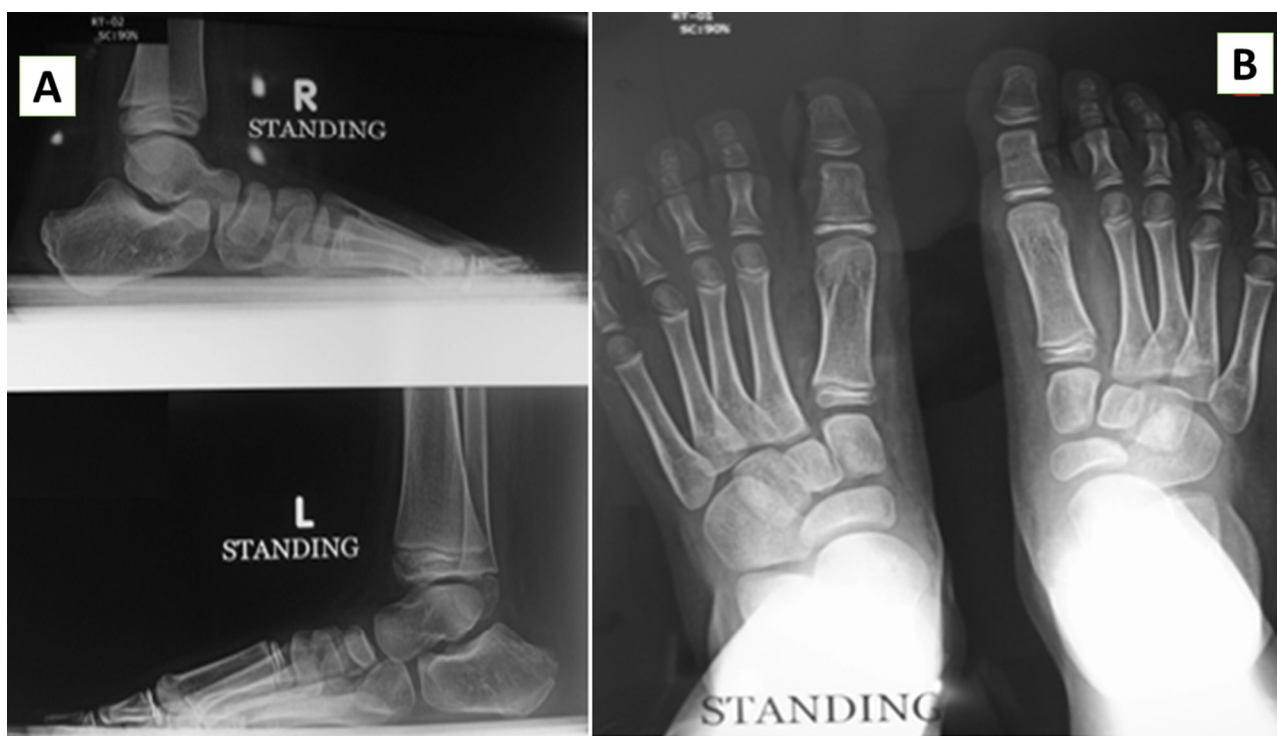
The radiograph of right unilateral talipes equinovarus of an eight-year-old child showing mild right-side residual varus compared with the left side. Weight-bearing lateral view (a) and anteroposterior view (b).
